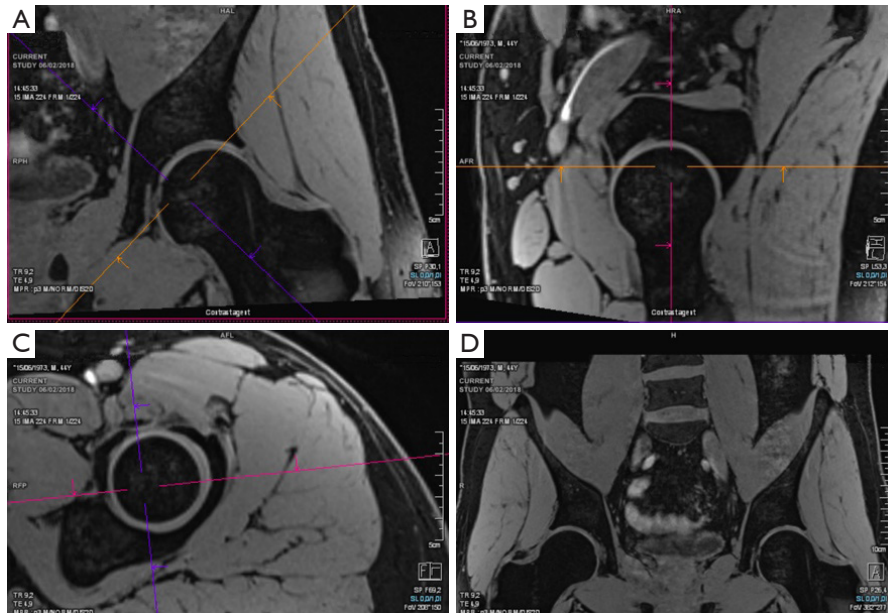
Measuring femoral torsion by MRI as a routine part of general hip workup. Femoral version is determined by the angle between the femoral neck axis and an axis parallel to the posterior aspect of the femoral condyles, measured in the transverse plane.
